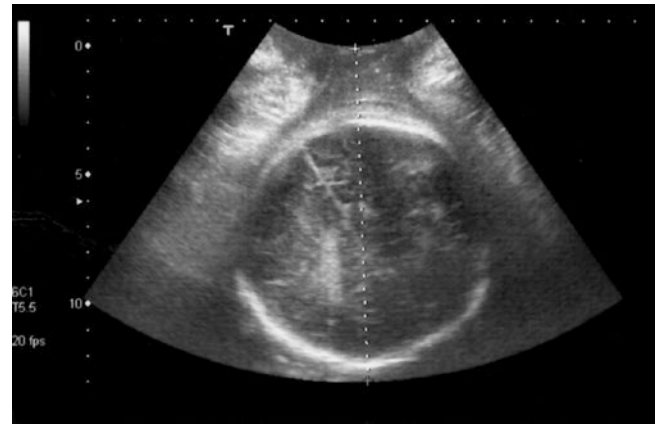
Translabial transverse ultrasonographic section of a malpositioned fetal head, as a consequence of internal rotation failure. In fact in this image, the fetal *midline* shows an angle with the symphysis pubis – sacral line (or anterior posterior pelvic line) $>45^\circ$. In this case, the fetal head is in occiput posterior position
